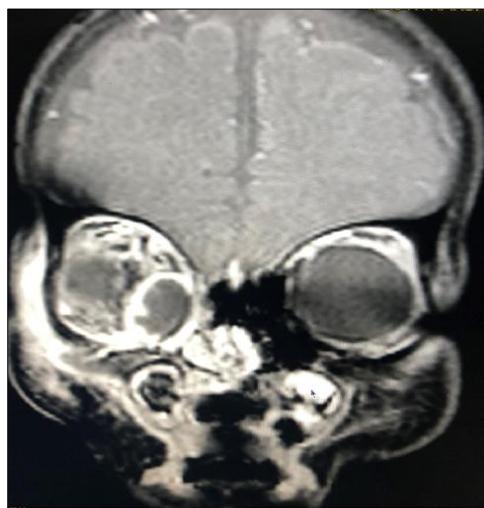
MRI orbit showing post septal right orbital cellulitis, subperiosteal abscess with right maxillary and ethmoidal sinusitis.
